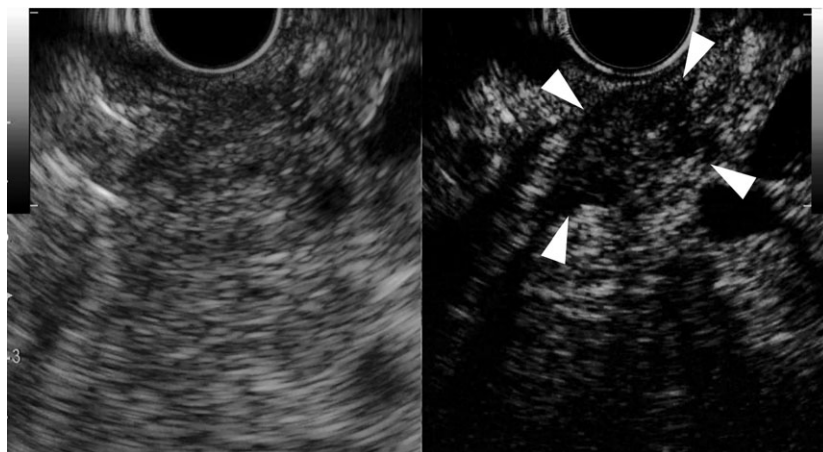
B-mode endoscopic ultrasonography (B-mode endoscopic ultrasonography [EUS], left image) and contrast-EUS (CH-EUS, right image) of a patient with an intraductal papillary mucinous neoplasm and concomitant pancreatic adenocarcinoma. B-mode EUS was unable to detect a solid tumor, whereas CH-EUS detected a hypovascular tumor, 8 mm in diameter (arrowheads).
